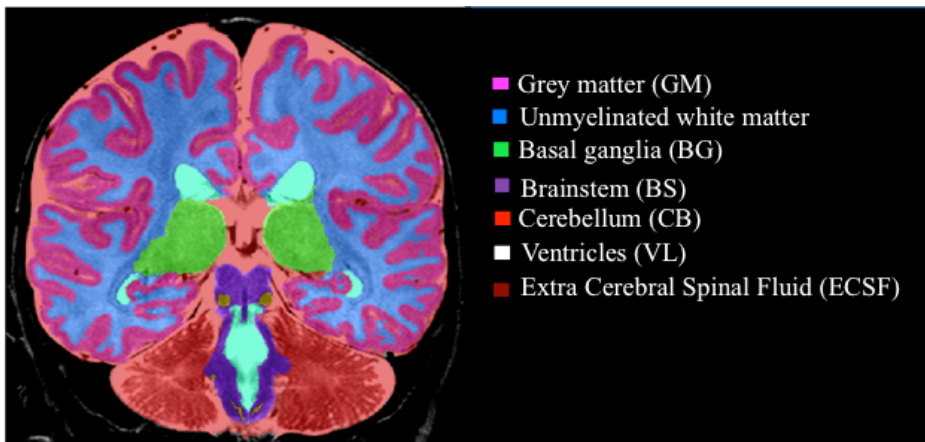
Example of tissue's segmentation on MRI
